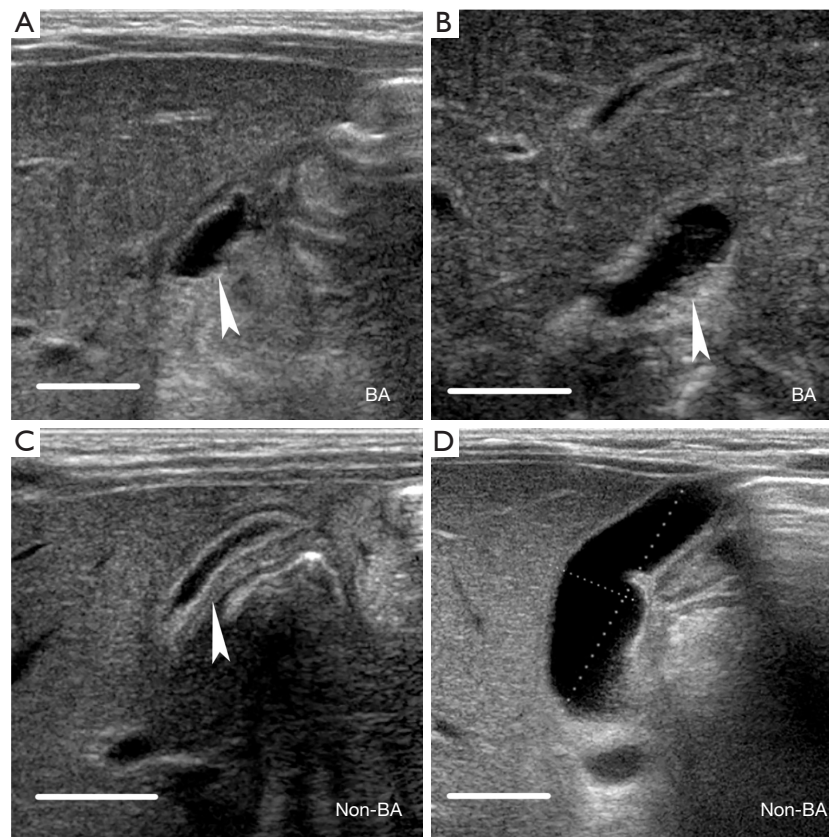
Longitudinal B-mode US images of gallbladder. (A) A 56-day-old girl with BA. US shows an abnormal gallbladder (arrowhead) 1.1 cm in length and a stiff and coarse inner wall. (B) A 55-day-old girl with BA. US shows an abnormal gallbladder (arrowhead) with a stiff and coarse inner wall. (C) A 23-day-old boy without BA. US shows a normal gallbladder (arrowhead) with an incompletely filled lumen but with a smooth and completely hyperechogenic mucosal lining. (D) A 55-day-old boy without BA. US shows a normal gallbladder 3.9 cm in length and 1.1 cm in width (calipers). Scale bar =1 cm. US, ultrasound; BA, biliary atresia.
